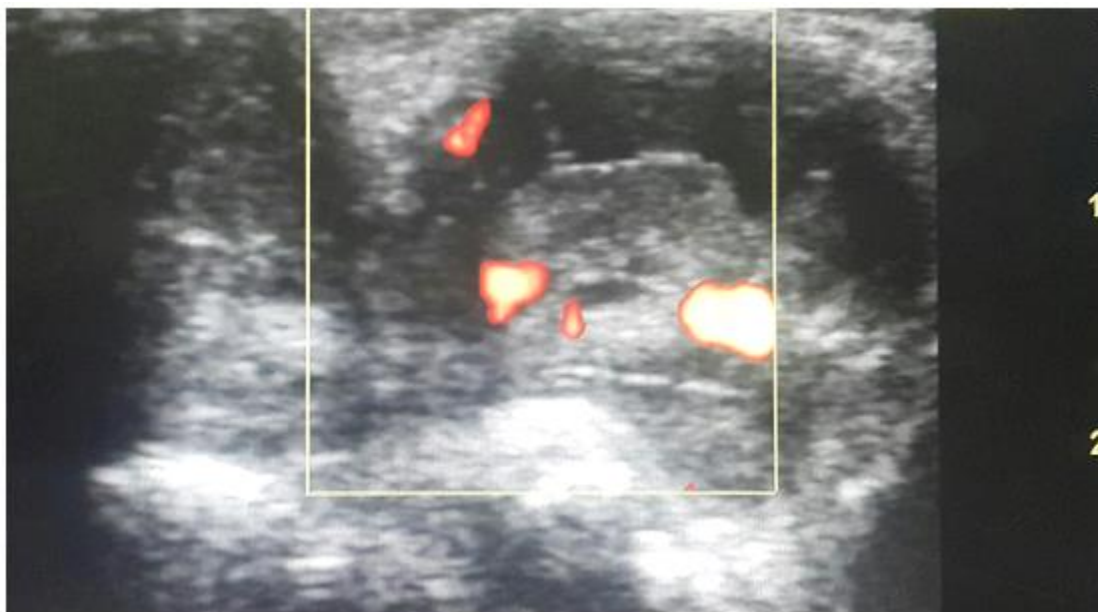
Ultrasound examination of the left wrist using an 8-13 MHz linear transducer significant synovial thickening with increased vascularity on doppler examination with multiple locular fluid filled compartments and floating hyperechoic shadows.
